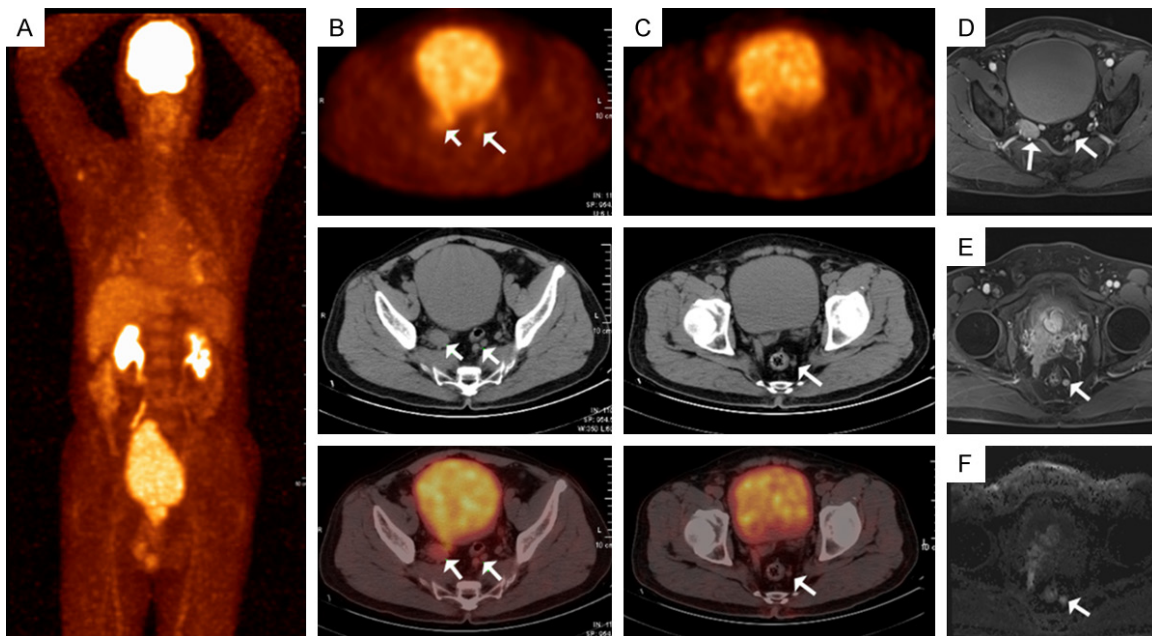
Concordant imaging findings of PET/CT and DWI-MRI in a 66-year-old patient with a Gleason sum 8 (4+4) prostate cancer. Multiple lymph nodes of bilateral internal iliac artery and sacral promontory showed increasing uptake of FDG with SUVmax of 3.5 and maximum diameter of 3.0 cm (A-C). These lesions also showed high signal intensity on T2 or DWI images with the maximum diameter of 3.2 cm (D-F).
